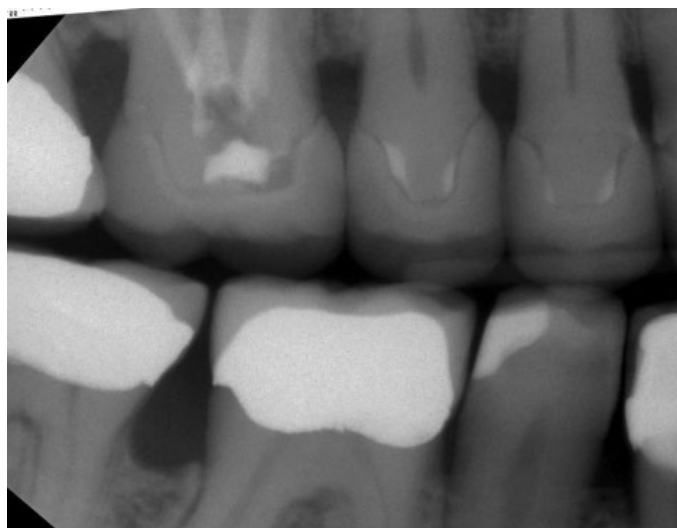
After the restorations are seated and adjusted for proper contact, margins are checked and verified by clinical examination. Next, a digital X-ray is made to confirm the interproximal marginal fit.
